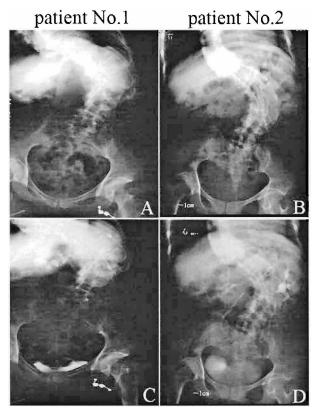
Follow-up radiographs at 3 months after MPCNL. KUB radiograph (A and B) and intravenous urography (C and D) revealed a calculus-free urinary tract.
